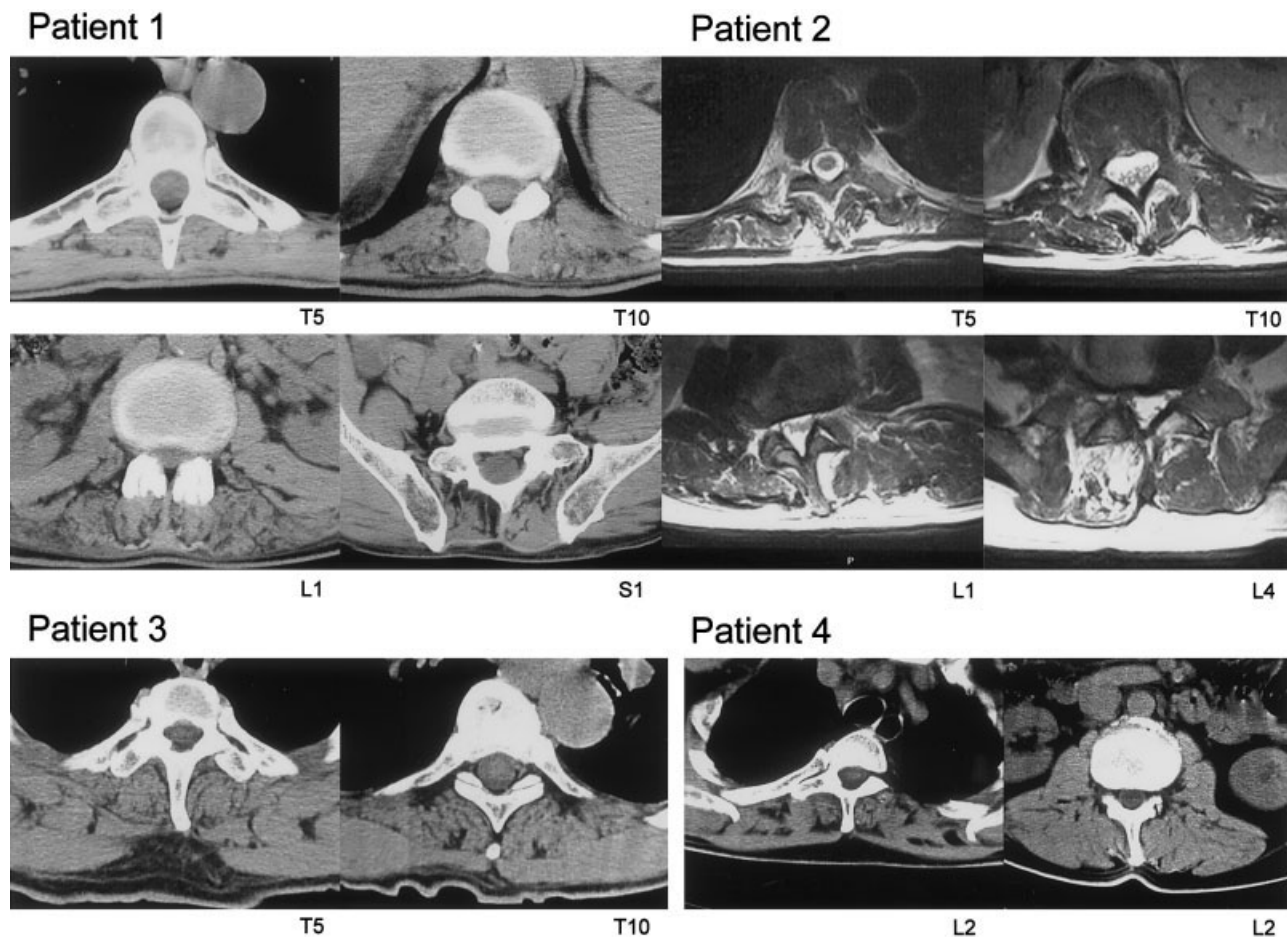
Computed tomographic (CT) and magnetic resonance imaging (MRI) scans of the thoracic and thoracolumbar spine in all 4 patients revealed no abnormalities of the spinal cord or the spinal column. In Patient 1 at and below the T10 level, the dorsal paraspinal musculature was diffusely interspersed with fat, pronounced on the right (<50%). The texture of the iliopsoas and gluteal muscles appeared normal. In Patient 2, MRI showed multifocal and asymmetric fatty replacement of paraspinal muscles between levels T5 and L4 (50–75%). In Patient 3, CT revealed the deep thoracic paraspinal musculature at the T5 to T10 levels on both sides mildly interspersed with fat (10–25%), whereas the superficial muscle layer appeared normal. In Patient 4, grade 2 fatty replacement of the deep thoracic paraspinal muscles with an asymmetric patchy pattern was evident (25–50%). Muscle texture at the lumbar levels appeared normal.
